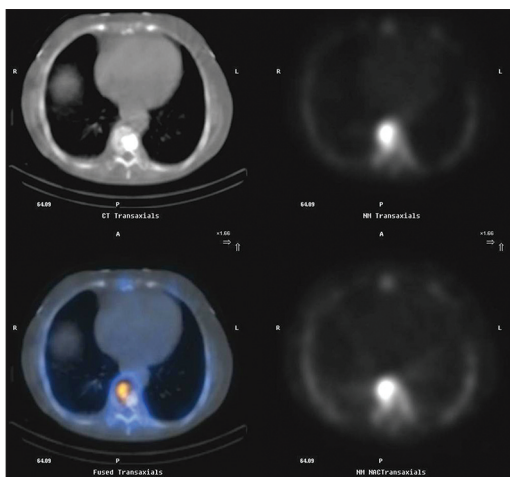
(a) Computed tomography image (upper left) showed multiple vertebral involvement (T7-T11) with bone cement in the previously treated vertebrae. (b) Bone scan images (upper right- attenuation corrected and lower right- attenuation not corrected) show mildly increased radiotracer uptake in the previously treated or old fractured vertebrae (T7-T10) and intense uptake in the T11 vertebra just below the previously treated vertebrae suggestive of fresh fracture. (c) Fused image (lower left) clearly identifies the previously treated and the newly fractured vertebra
